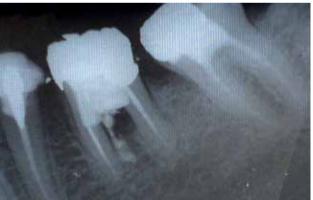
Radiographic image of the involved tooth before treatment.
